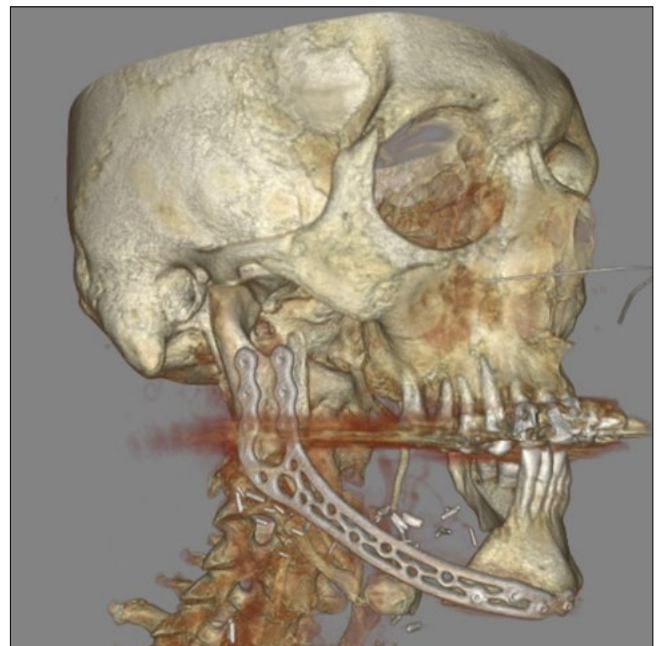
3D-reconstruction of the postoperative CBCT
